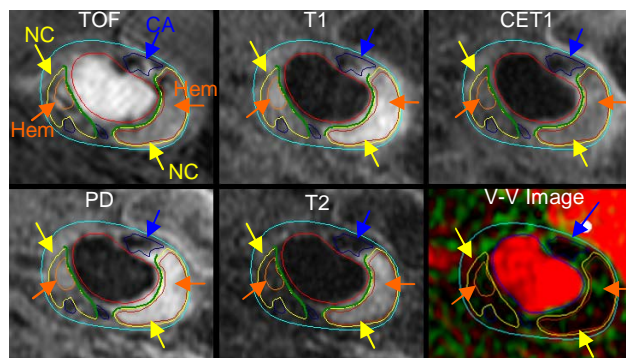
TOF, T1, CET1, PD, T2 weighted MR images and Vasa Vasorum Image with contours of plaque components (arrows).
